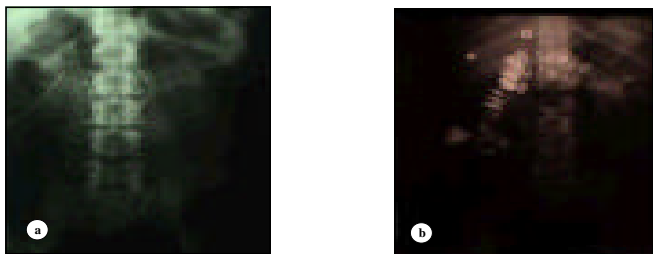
Post operative kidney, ureter and bladder (KUB) radiograph and fistulography: a) stone free KUB. b) cutaneous colonic fistula "fistulography".
